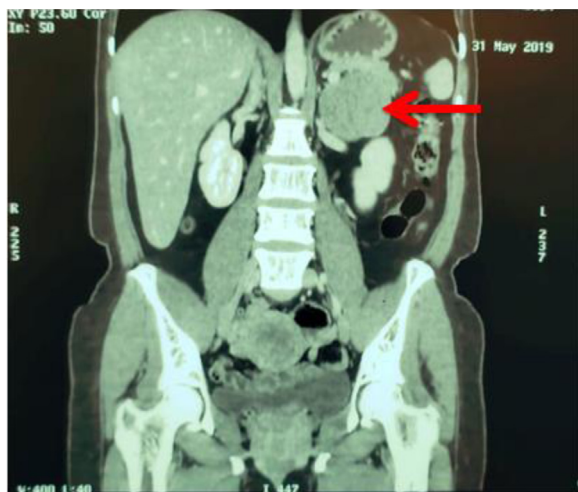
CT scan image showing an Adrenal "Incidentaloma".
